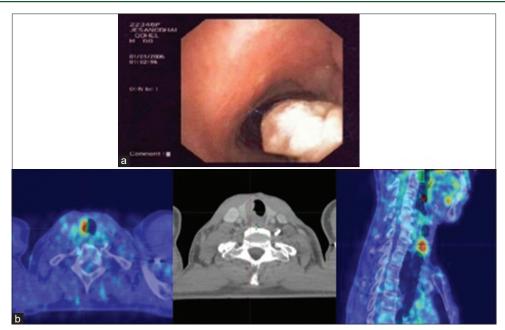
Bronchoscopy (a) shows growth on the posterolateral wall that partially occludes the endotracheal lumen. Positron emission tomography/computed tomography images (b) showing 18F-fluorodeoxyglucose-avid tracheal growth on the right side, abutting the right lobe of the thyroid gland at the level of C7-D1 vertebral level
